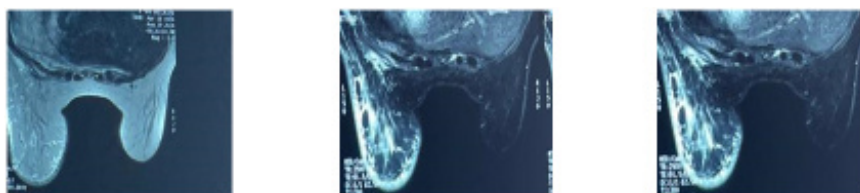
Image MRI showing axillary and internal mammary lymphadenopathy with discrete micronodular infiltration pre-pectoral fat classified ACR4.
